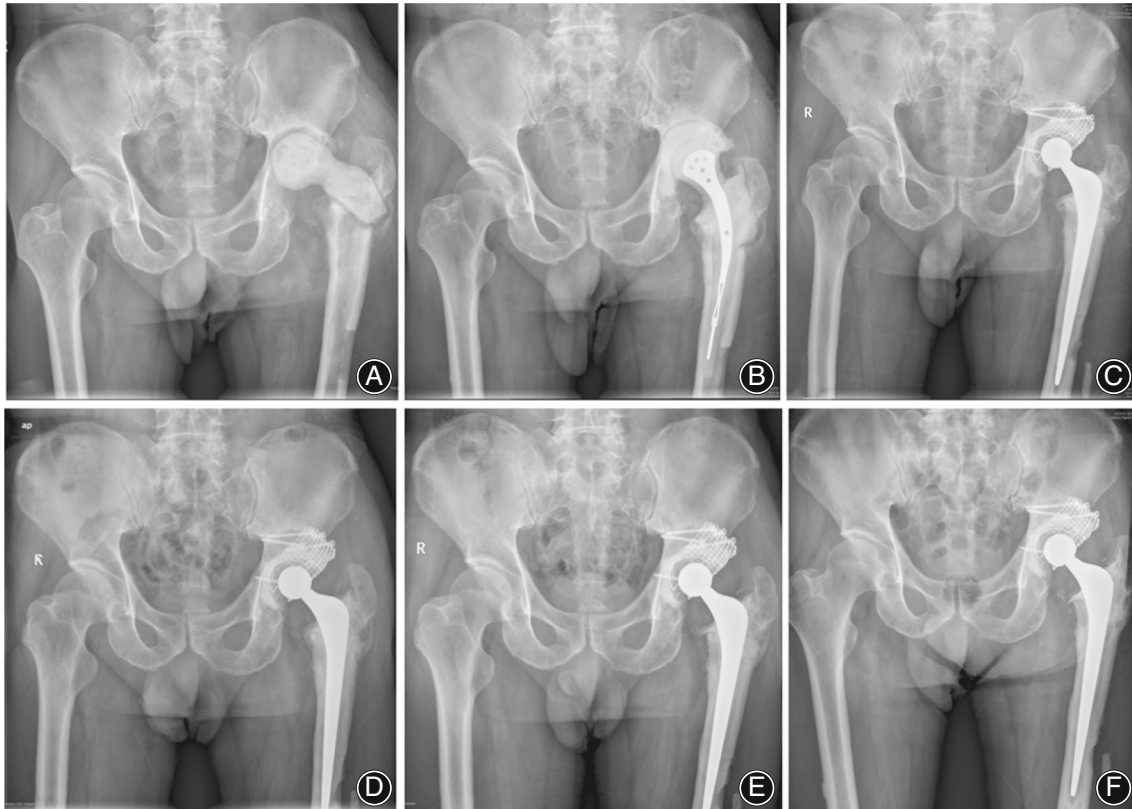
(A–F) Preoperative and follow-up radiographs of the left hip joint in a 66-year-old male. (A,B) A 66-year-old male suffered a fracture of the left femoral neck 2 years ago. Radiography at 3 months after he received the first THR shows a failed spacer implanted in another hospital, and the infection is not under control, then underwent a hip debridement and implanted a new spacer in our hospital. (C) Radiography at 1 week after he received a revision THR using IBG and a mesh to reconstruct the acetabular defect on the left hip. (D–F) Radiograph at 24, 36, 60 months after the revision surgery on the left hip shows no radiographic loosening or cup migration.
